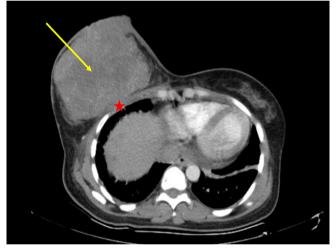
Computed tomography scan showing a large, infiltrative and necrotic tumor of the right breast (arrow) with invasion of the underlying pectoral muscle (asterisk)
